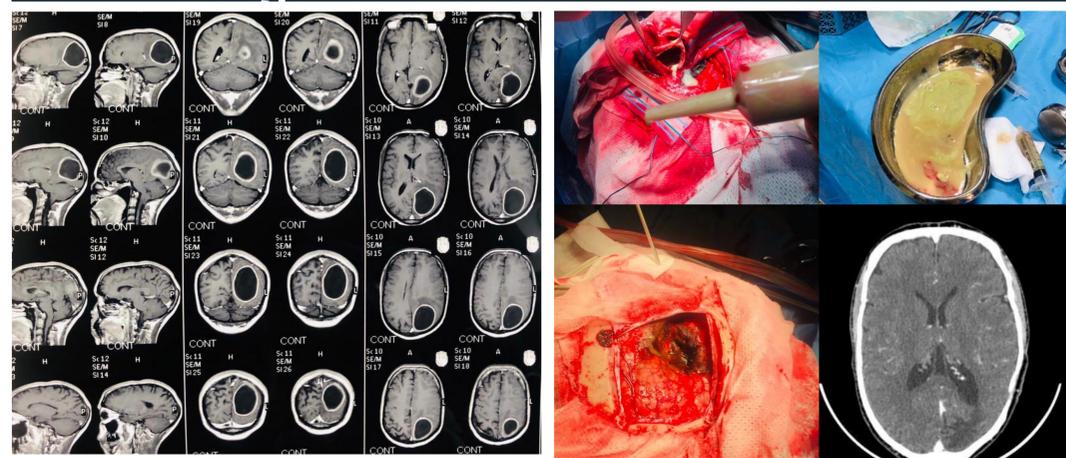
Pre-operative MRI brain with contrast showing a left-sided occipital brain abscess.
